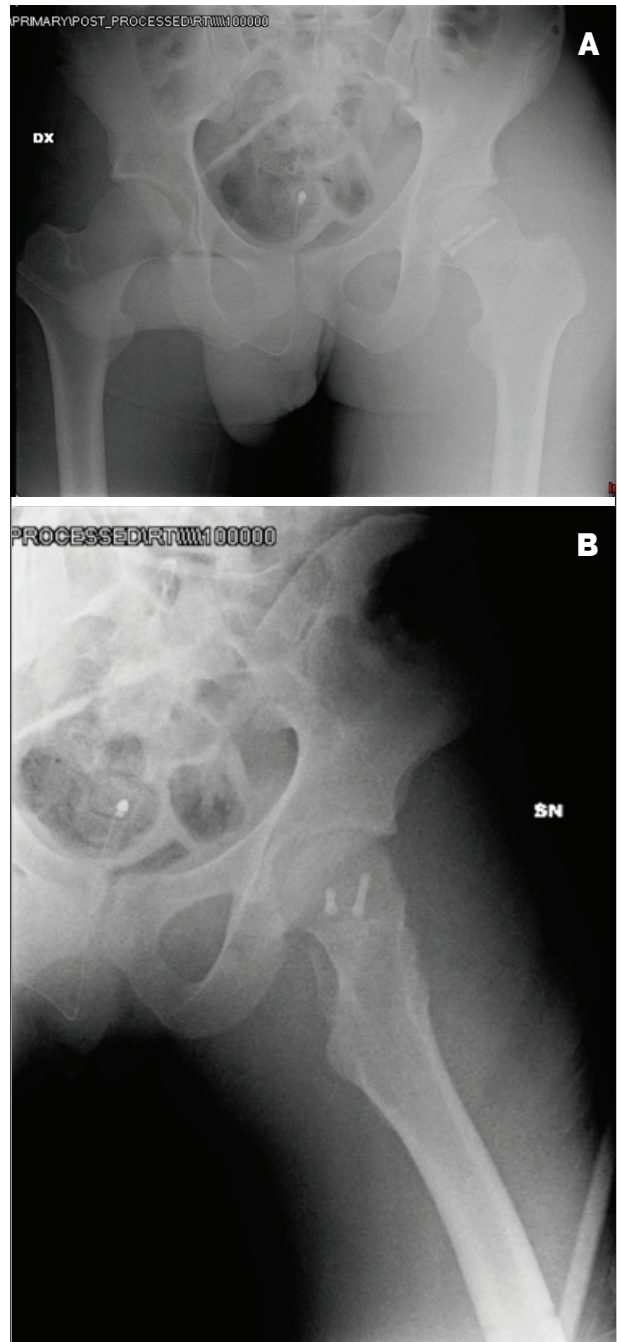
anteroposterior (A) and lateral (B) post-operative X-rays showing the achieved reduction and fixation of the femoral head fragment
